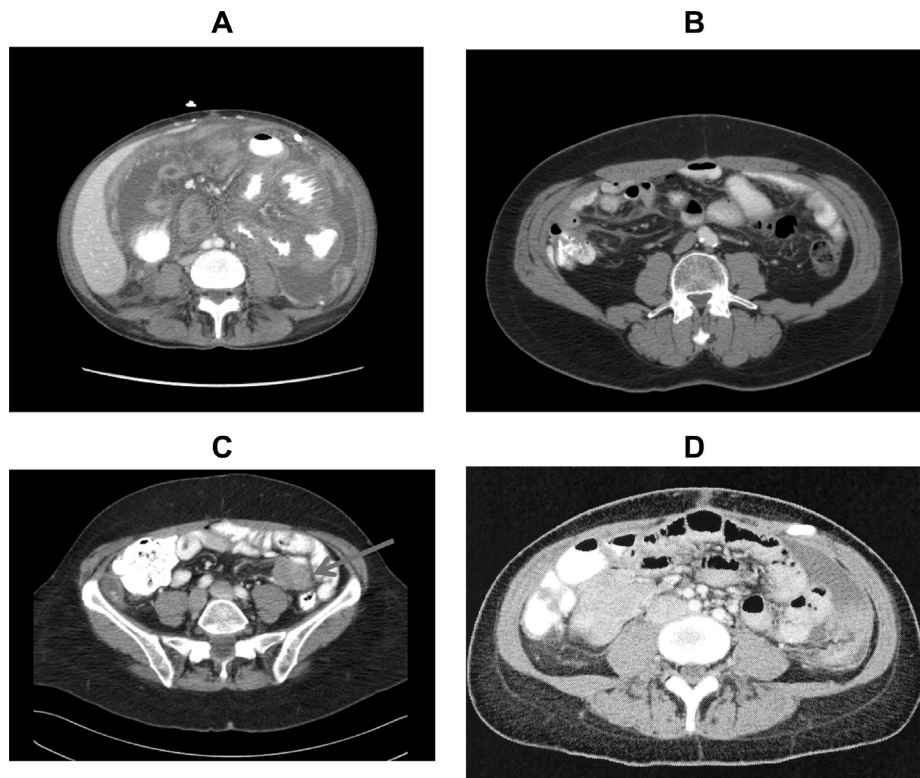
Interpretative radiologic findings of recurrent malignant peritoneal mesothelioma by CT. A – Class 1 CT shows a gross ascites accumulation throughout the abdomen and pelvis. B – Class 1 CT shows a small volume of ascites between folds of small bowel mesentery in the terminal ileum. C – Class 2 CT shows a discrete left lower quadrant mesenteric soft tissue mass. D – Class 3 CT shows multiple mesenteric nodules and a mass present in the left paracolic sulcus.
